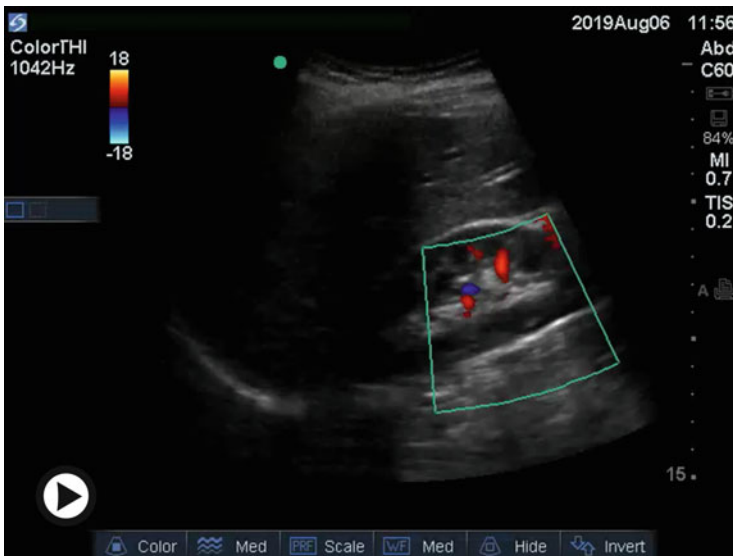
(Video 7.5) In this video, Color Doppler has been applied to demonstrate blood flow in the renal sinus (► <https://doi.org/10.1007/000-7q9>)
